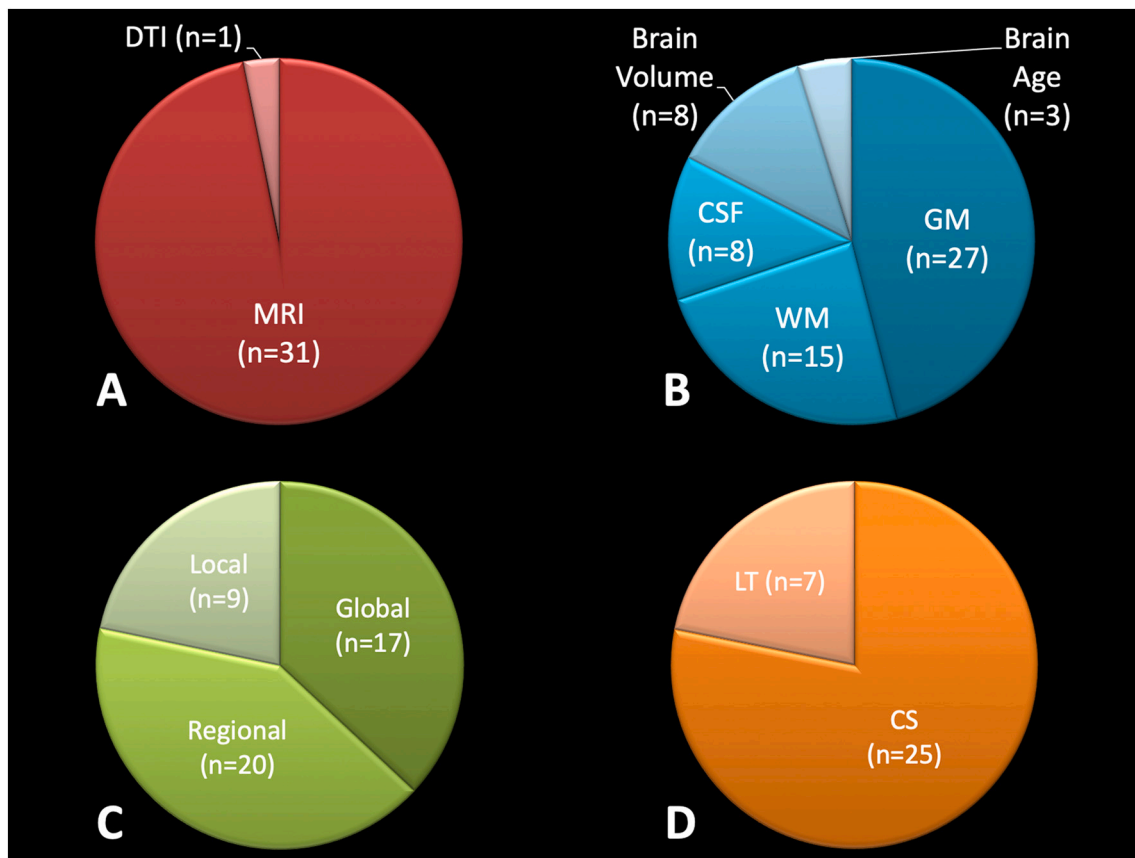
Study-specific Characteristics. Panel A: Different imaging modalities (MRI = magnetic resonance imaging; DTI = diffusion tensor imaging). Panel B: Different targets (GM = gray matter; WM = white matter; CSF = cerebral spinal fluid). Panel C: Different spatial scales. Panel D: Different study designs (CS = cross-sectional; LG = longitudinal).
